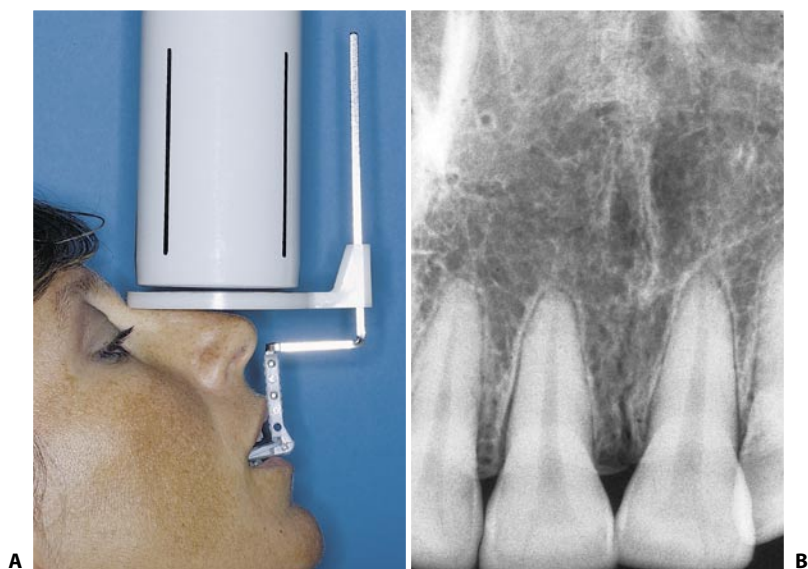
A. The mandible is not protruded, the corner of the plastic support is outside the mouth, and the X-rays are perpendicular to the radiograph but not to the long axis of the tooth. B. A shortened image results.
